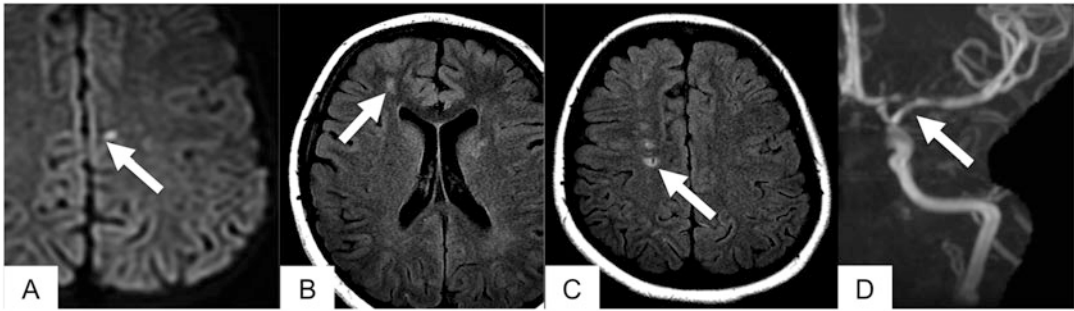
Sickle cell vasculopathy. A 13-year-old female with history of sickle cell disease presented with an acute infarction in the left parietal lobe, seen best on DWI (a). Multiple chronic infarctions were also demonstrated on T2W FLAIR in the right frontal lobe (b, c). 3D
